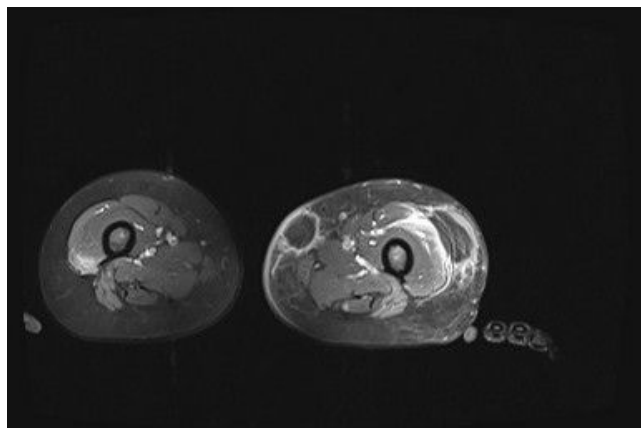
(B): MRI at diagnosis: left limb
